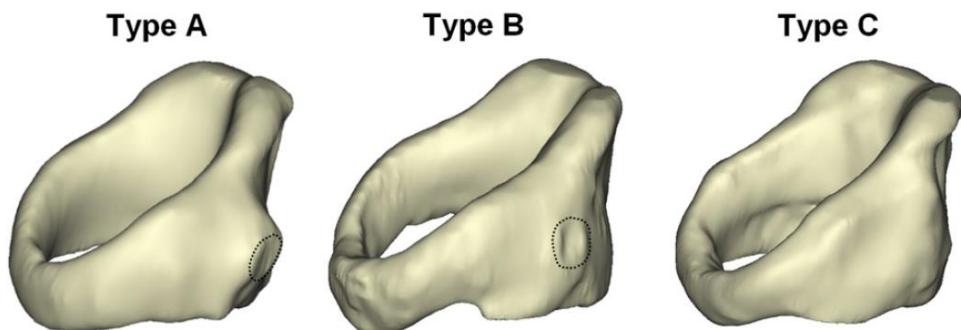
CT joints according to Maue and Dickson (1971). Oblique view of three cricoid cartilages: Type A shows a well-defined joint surface; Type B shows a flat joint surface, with only a tiny protuberance; Type C shows no definable joint surface (Storck, et al., 2011; used with permission from Elsevier)
